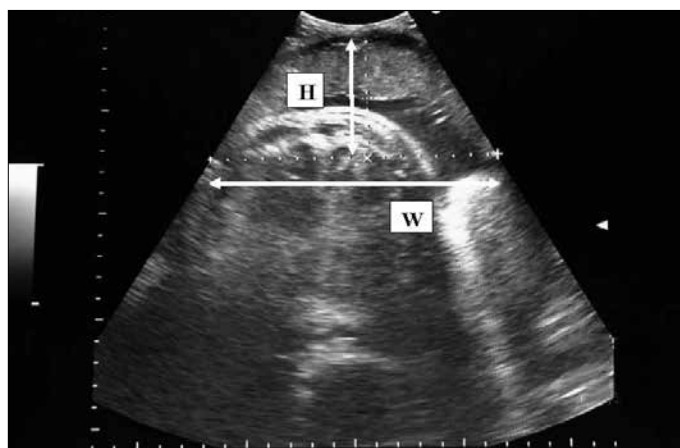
A two-dimensional ultrasound scan showing the measurement of placental width (W) and placental height (H) in centimeters
